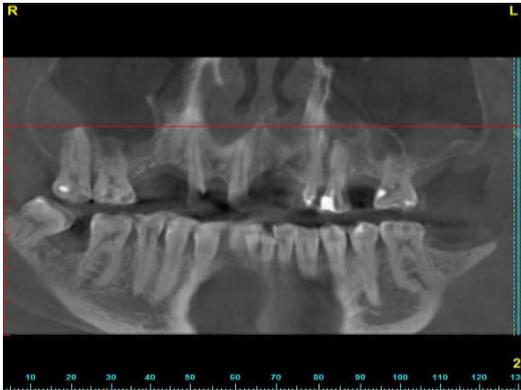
Initial panoramic x-ray
